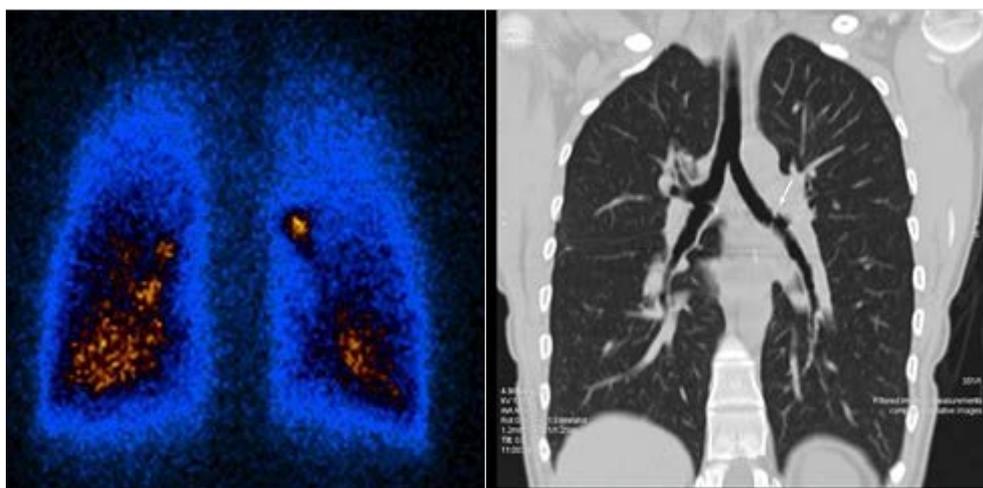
Ventilation (a) and perfusion (b) scintigrams (posterior view) of patient SRV, 37 years old, on day 85 after bilateral lung transplantation demonstrated a focal delayed transit of the inhaled radiopharmaceutical at the level of the left main bronchus and pronounced hypoventilation of the right lung lower segments; a moderate decreased diffused perfusion in the inferio-posterior segments of both lungs
